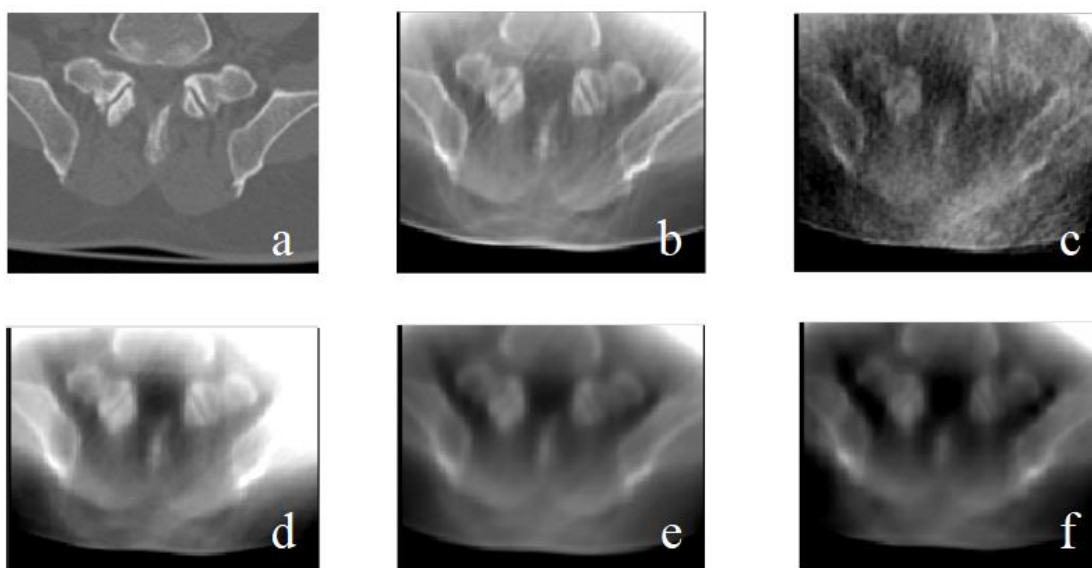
Example of axial view for different methods. (a) planning CT, (b) FDK, (c) SART, (d) OS-SART, (e) ADMM-TV, (f) ADMM-W.
